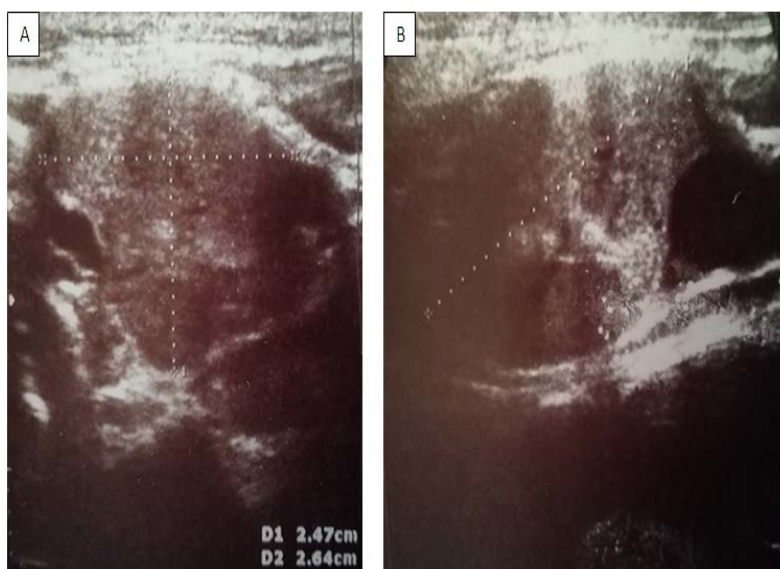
Ultrasonic finding: heteroechoic, dominant hyperechoic change, relatively clearly limited.
